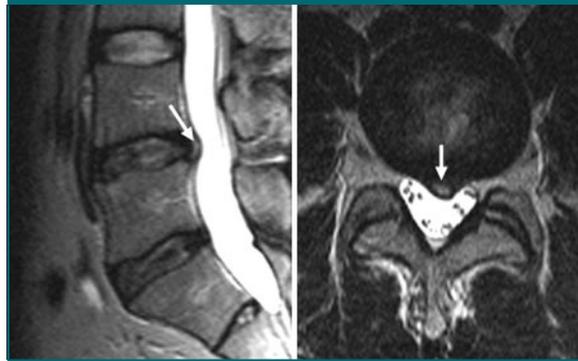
Protruded herniated disk. Sagittal (left) and transverse (right) T2-weighted fast SE (4000/120) images through lower lumbar spine and L4-5 disk level. Note convex posterior margin on left image (arrow). Protruded disk herniation is characterized by broader base than the extension of disk material beyond the disk space (arrow).
